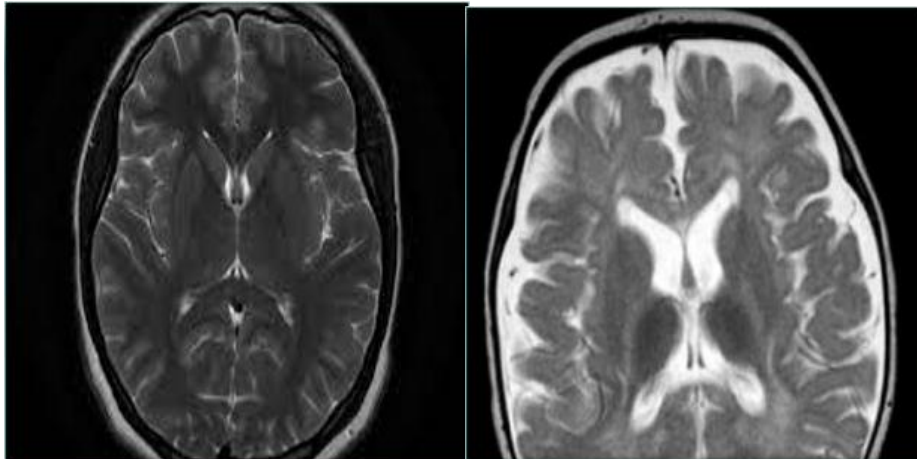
MRI of normal human brain (L) and Krabbe disease(R).
